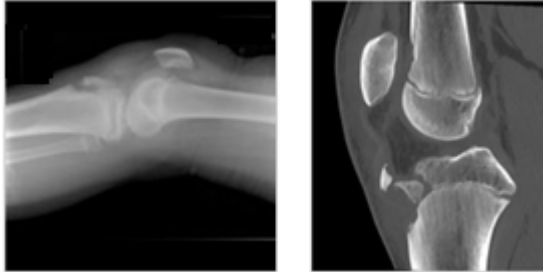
TIBIAL TUBEROSITY AVULSION. Left knee radiographs. A, mild separation. B, severe separation affecting the joint.
